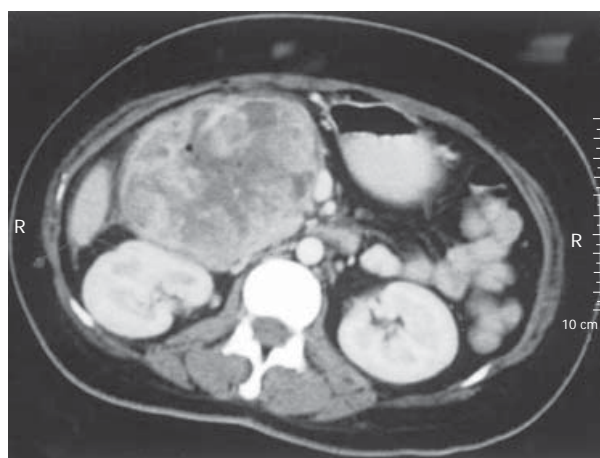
Computed tomography showing a 10 cm x 15 cm oval, mildly hypoechoic tumor with smooth margins.
